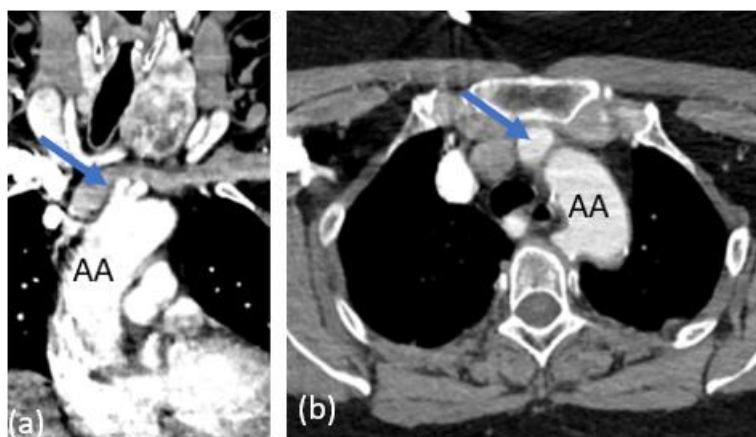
Contrast enhanced CT coronal (a), (b) and axial (c) views and 3D volume rendering image - posterior oblique view (d) demonstrating Right sided aortic arch (AA), Kommerell diverticulum (KD) and origins of right subclavian artery from the anterior aspect of arch (in axial image) and aberrant left subclavian artery from Kommerell diverticulum
